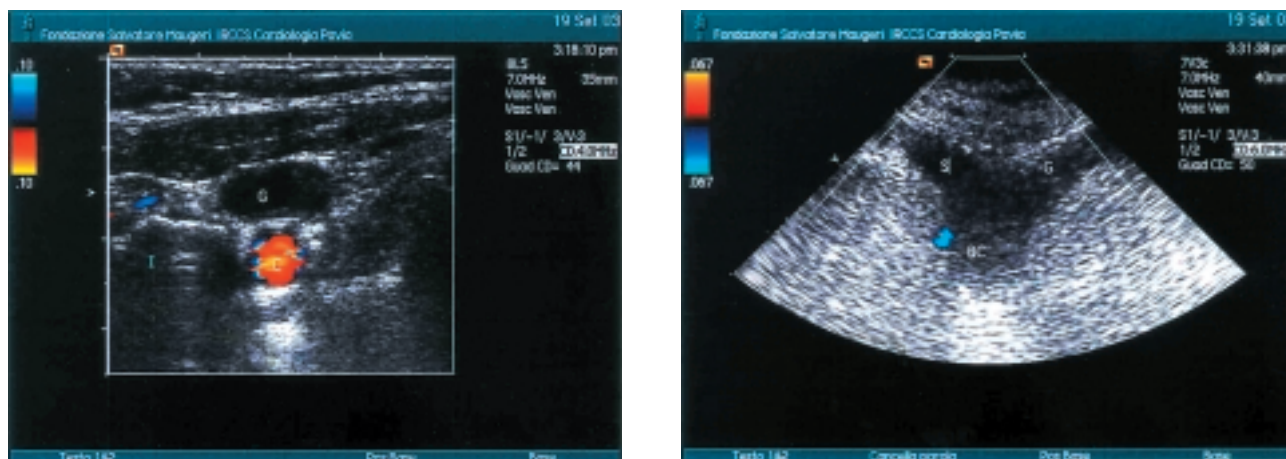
Neck ultrasound testing demonstrating left jugular (G), subclavian (S), and brachiocephalic (BC) vein thrombosis. There is a lack of full compressibility without the intraluminal color Doppler signal (left panel). Because the BC vein (right panel) cannot be tested for compressibility due to the presence of the clavicle, the only pathologic finding is no flow. C = carotid artery.
